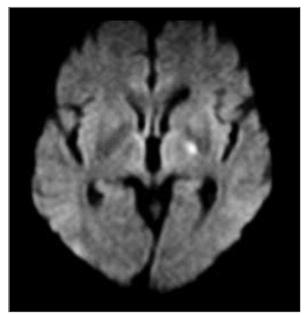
Axial diffusion-weighted magnetic resonance imaging shows an acute left capsulothalamic infarct.
